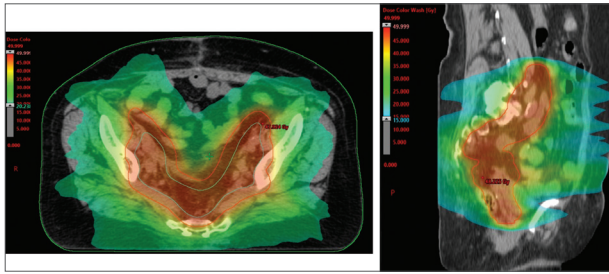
Axial and sagittal CT planning of external radiotherapy. The patient received a dose of 45 Gy to pelvis, in 25 fractions, with an intensity-modulated radiation therapy technique.
